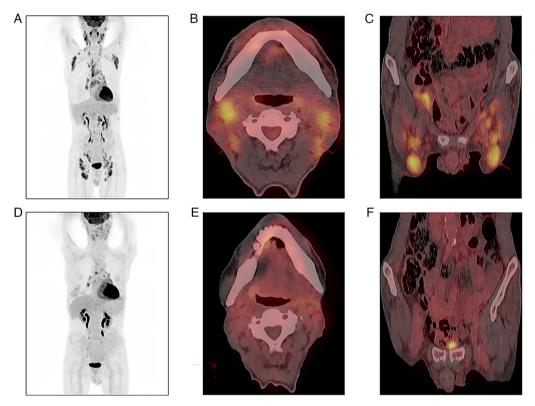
Initial PET-CT showing increased FDG metabolism in multiregional lymph nodes. (A) Whole body PET-CT. (B) Neck and (C) inguinal lymph nodes. Mildly increased FDG metabolism in multiregional lymph nodes was observed following treatment, assessed as CR. (D) Whole body PET-CT. (E) Neck and (F) Inguinal lymph nodes. The arrows point to the areas of increased FDG uptake. PET-CT, positron emission tomography/computed tomography; FDG, fluorodeoxyglucose.
